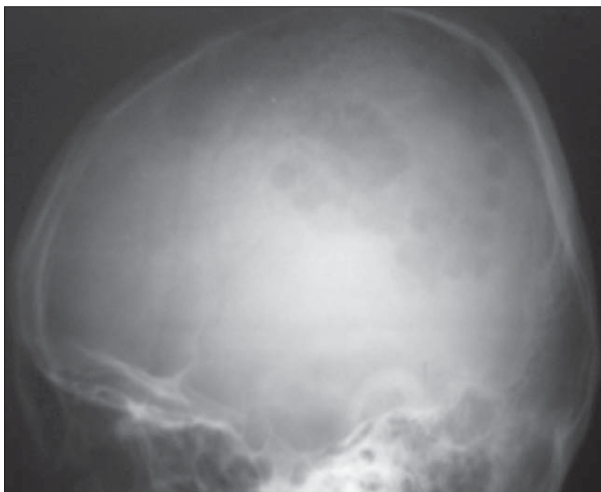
Patient A. X-ray film, side projection, in 3 weeks after trauma – zone of skull bone destruction
